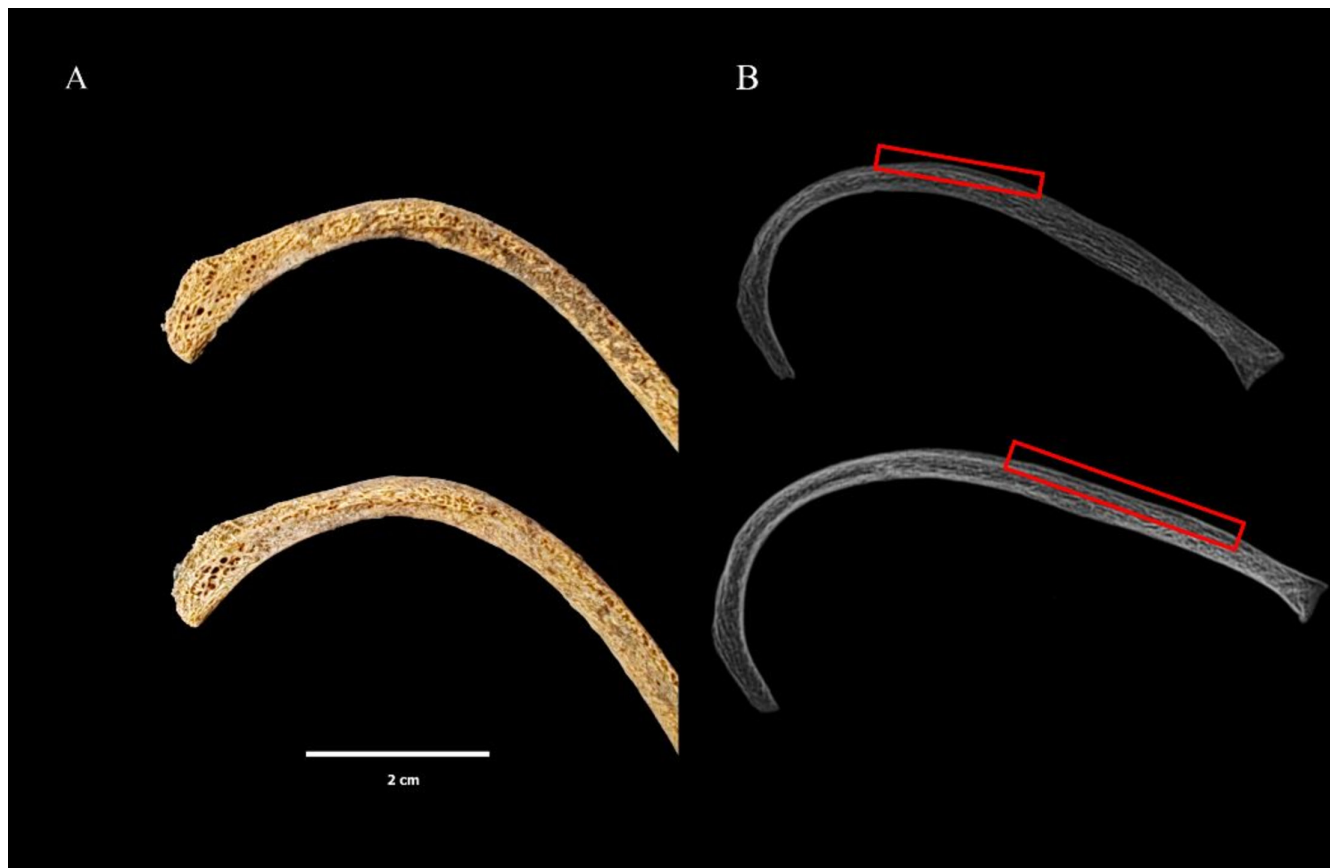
(A) Ribs are thickened with accentuated pitting along the costal margin; the surface shows extreme lacelike cortical rarefaction. (B) X-ray image showing thick layers of subperiosteal new bone on the rib shafts, with ribs exhibiting a “rib-within-a-rib” appearance. [Colour figure can be viewed at [wileyonlinelibrary.com](https://onlinelibrary.wiley.com)]
